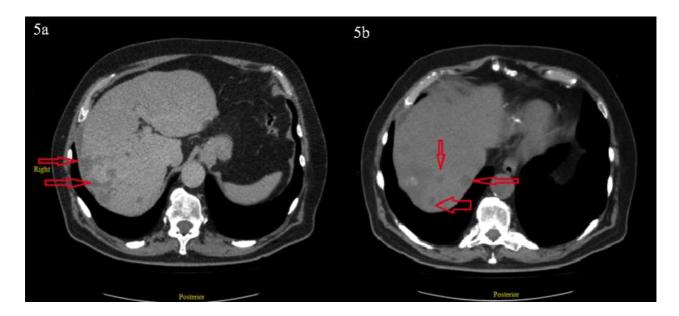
The computed tomography of the patient performed in March of 2014.
